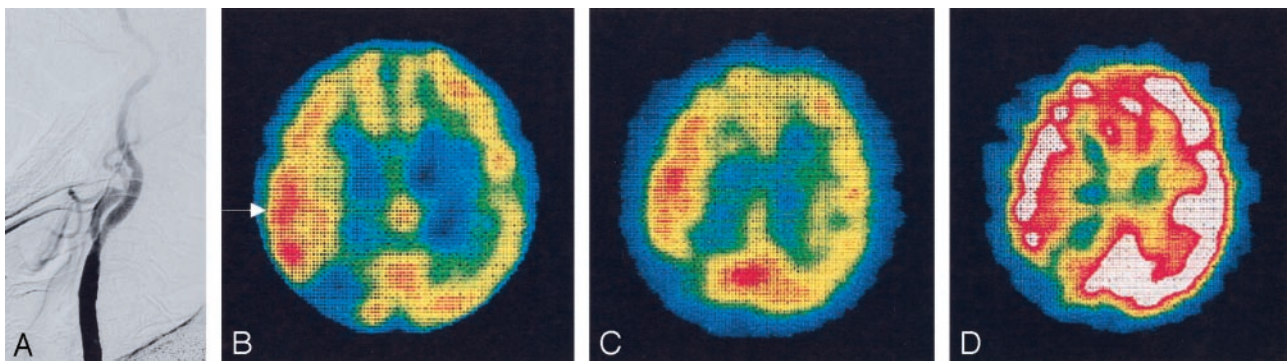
Images obtained in an 83-year-old man with cerebral hyperperfusion after carotid stent placement. A, Postprocedural carotid angiogram shows satisfactory dilatation of the right internal carotid artery with normalized distal blood flow. B, $^{99\text{m}}\text{Tc}$ -HMPAO SPECT scan obtained immediately after stent placement shows hyperperfusion in the right MCA territory, with an asymmetry index of 120.3% (arrow). C, ^{123}I -IMP SPECT scan in the resting state obtained 7 days after stent placement shows prolonged hyperperfusion in the territory, with an asymmetry index of 108.1%. D, ^{123}I -IMP SPECT scan obtained with an ACZ challenge 7 days after stent placement shows a slightly improved but still impaired cerebrovascular reserve of 13.4% in the right cerebral hemisphere.
